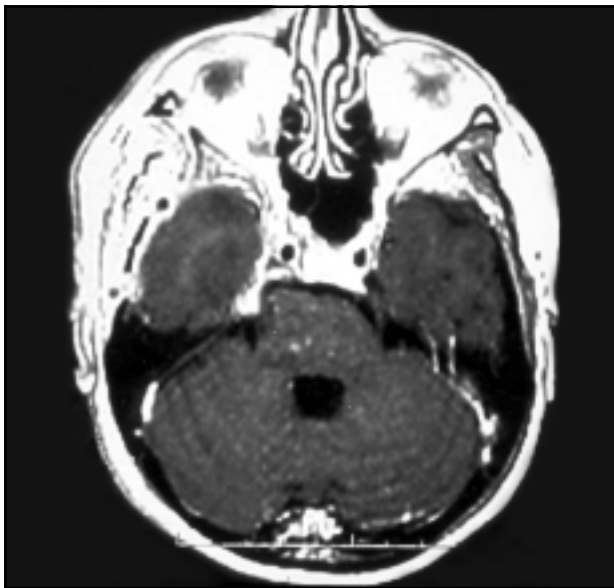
FLAIR weighed MR image showing complete resection of the lesion.
